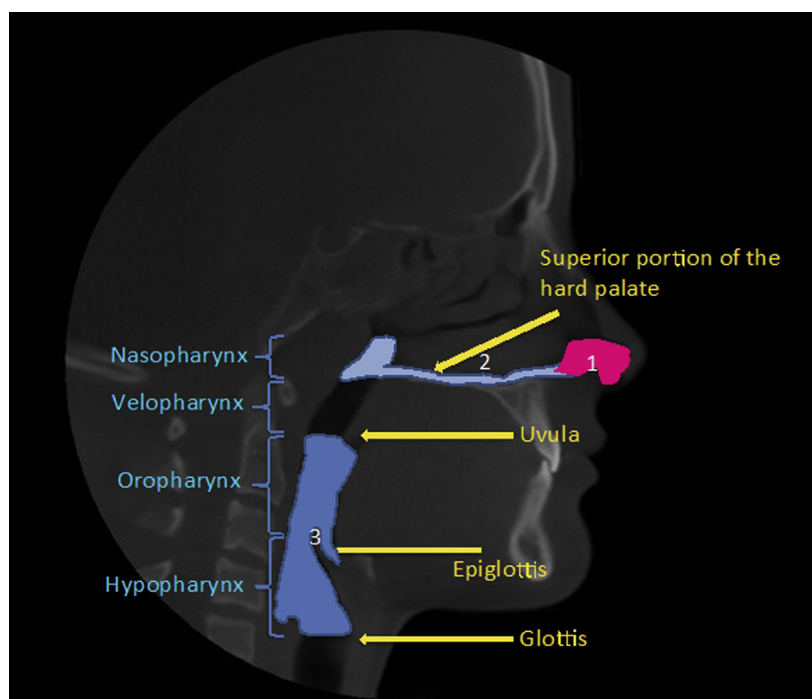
Radiographic anatomy of the upper airway: 1, anterior nasal valve volume; 2, total nasal volume; 3, pharyngeal volume.
